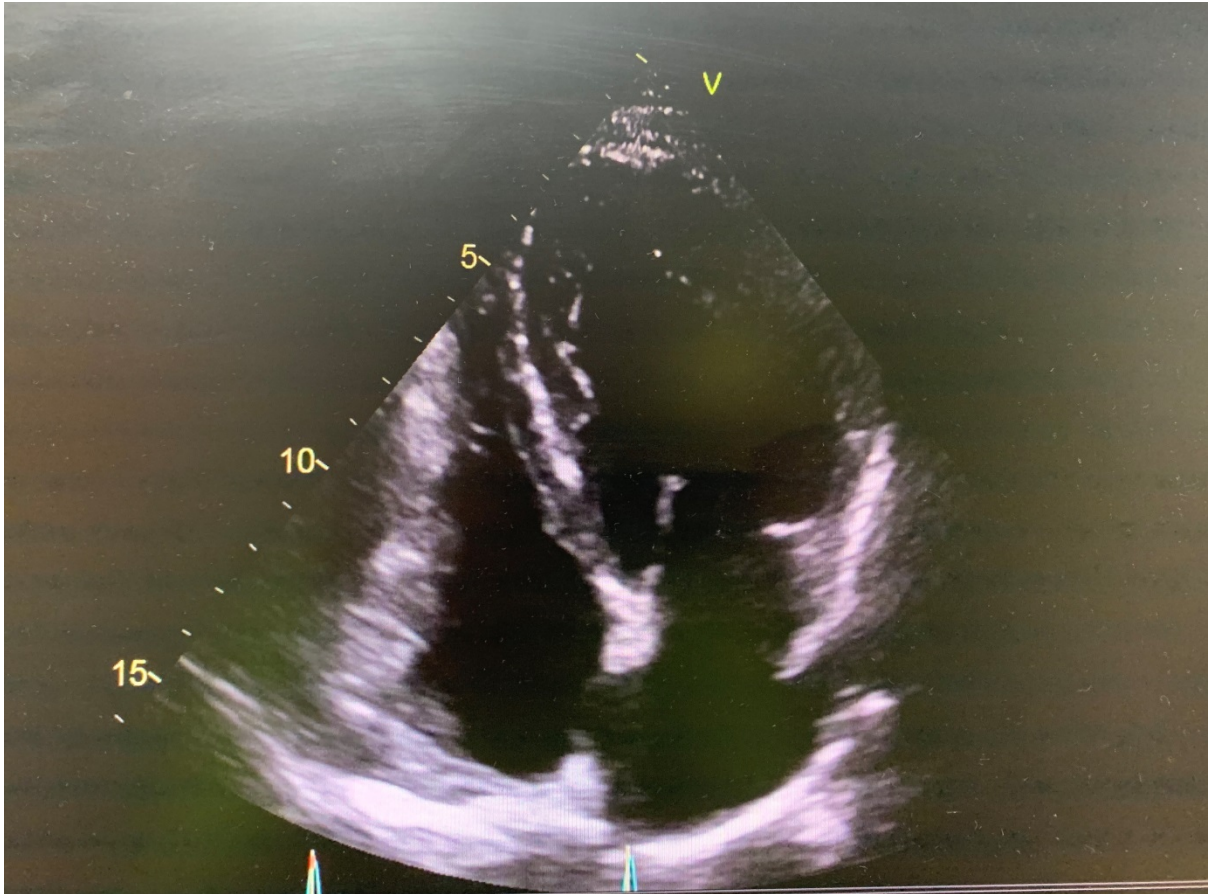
Two-chamber view on 2D transthoracic echocardiogram in end-systole; patient left ventricle has remodeled significantly with reduction in LV and RV volume, and decreased size of atria after discontinuation of Tacrolimus and switch to Sirolimus. Ejection fraction by Simpson's biplane method 49%.
